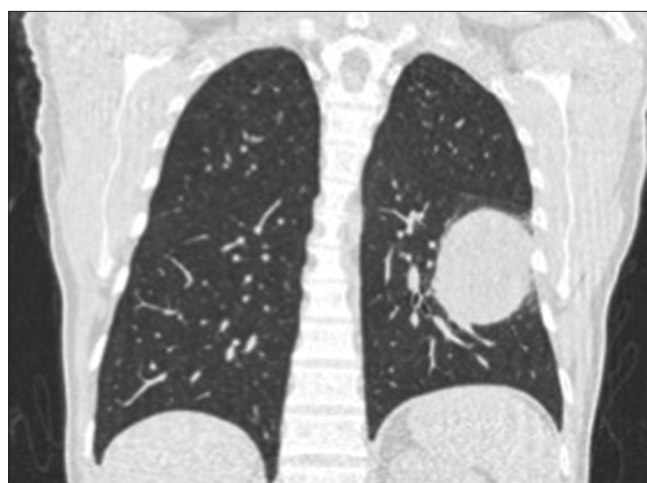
Chest computed tomography with coronal plane shows the tumor mass found in the left lung. The patient did not present pulmonary symptoms, it was considered an incidental finding, which was later confirmed to be associated with the primary tumor.
